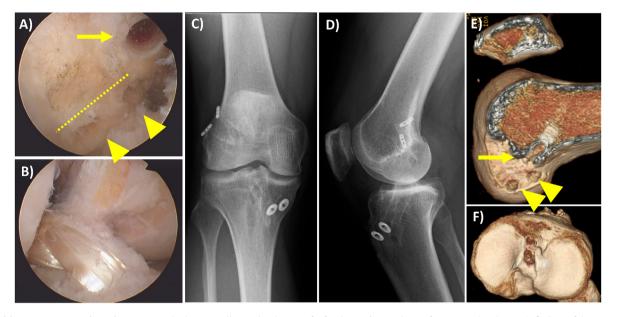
Revision ACL reconstruction using a rectangular bone-patellar tendon-bone graft after hamstring tendon graft rupture. A) Arthroscopic findings of the primary surgery interference screw hole (Arrow) and femoral tunnel of revision surgery (arrowhead) created behind the Resident's ridge (dotted line). B) Arthroscopic findings of revision ACL reconstruction. C, D) Postoperative anteroposterior and lateral radiographs. E, F) Femoral tunnel and tibial tunnel positions in postoperative 3-dimensional computed tomography.
